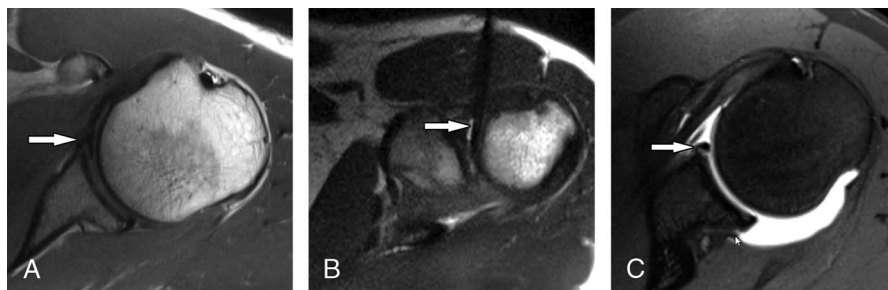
Magnetic resonance imaging–guided 3.0-T magnetic resonance arthrography of the left shoulder in a 32-year-old American football player with chronic shoulder pain. A, Diagnostic axial proton density–weighted TSE MRI scan without intra-articular contrast shows a coapted anteroinferior labrum (arrow). B, Interventional axial proton density–weighted TSE MRI scan demonstrating intra-articular glenohumeral needle puncture (arrow) through the rotator interval for intra-articular MR arthrographic injection of gadolinium-enhanced sterile saline. C, Diagnostic axial fat-suppressed T1-weighted TSE magnetic resonance arthrography image unmasks a small Perthes lesion of the anteroinferior labrum (large arrow), whereas the posterior capsular attachment is intact (small arrow). Combined diagnostic and interventional MRI were obtained with a commercial 3.0-T MRI system (slow rate, 200 T/m/s; gradient strength, 45 mT/m) and a dedicated 16 receiver channels shoulder surface coil.
